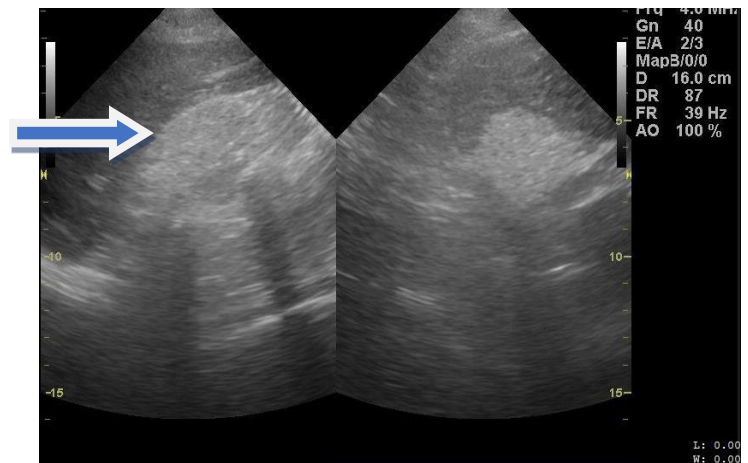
Longitudinal ultrasound scan image of grade (III) renal echogenicity with loss of central sinus echogenicity (blue arrows) and corticomedullary differentiation in a 64-year-old male with HIV-associated nephropathy. Note the shrunken kidney.
